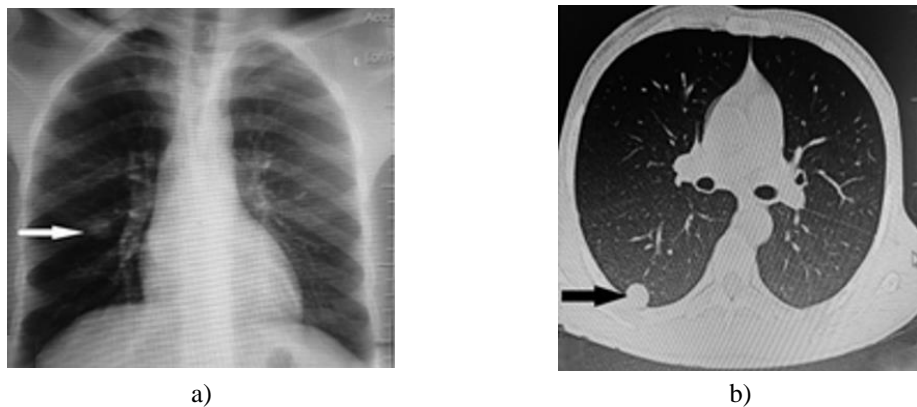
Chest X-ray and computed tomography scan of the metastatic lesions; a) X-ray showing a solitary nodular opacity in the middle zone of the right lung (white arrow), b) Computed tomography showing a soft-tissue mass in the posterior aspect of the right lung presenting as a nodule (black arrow).
